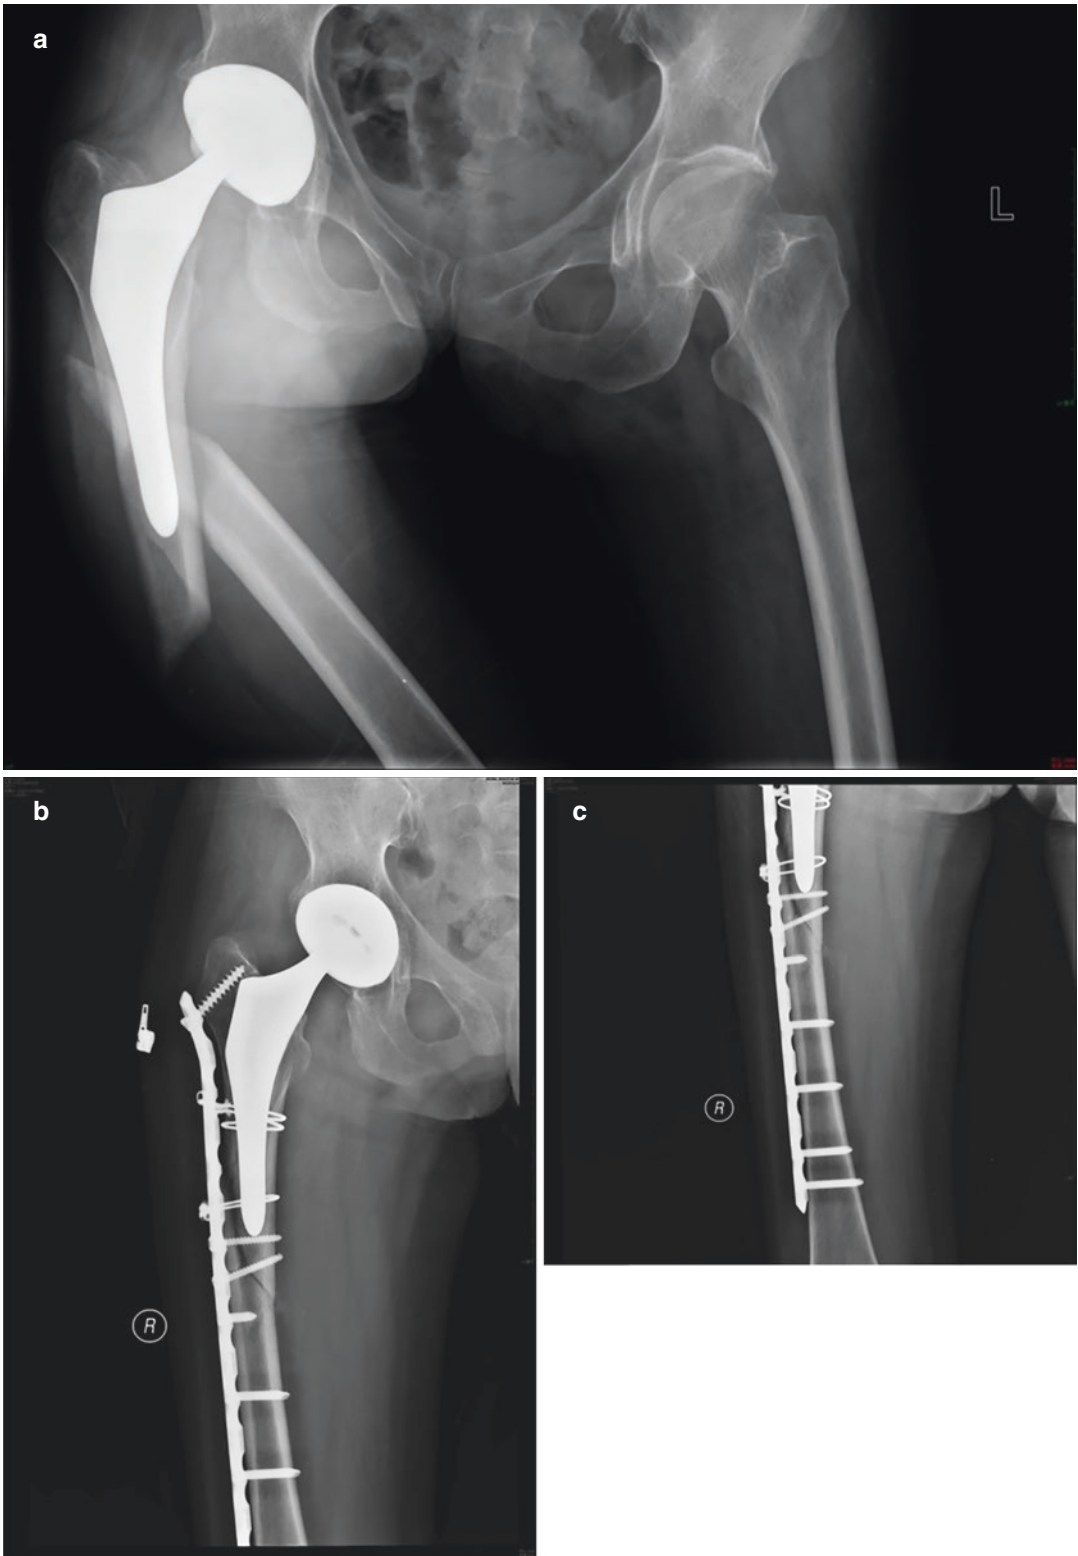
Radiograph of a periprosthetic femoral fracture type B1. (a) Preoperative image showing the fracture just distal of the stem tip. (b, c) Postoperative image after treatment with a locking compression plate
